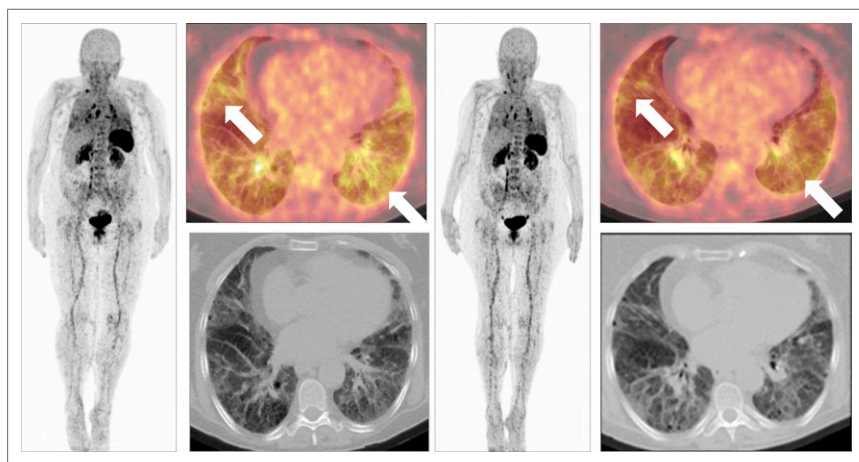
^{68}Ga -pentixafor PET/CT in assessment of pirfenidone treatment of idiopathic pulmonary fibrosis. Example of 59-year-old woman before (left; $\text{SUV}_{\text{peak}} = 3.1$, $\text{SUV}_{\text{mean}} = 2.5$) and after (right; $\text{SUV}_{\text{peak}} = 2.7$, $\text{SUV}_{\text{mean}} = 2.2$) therapy.
